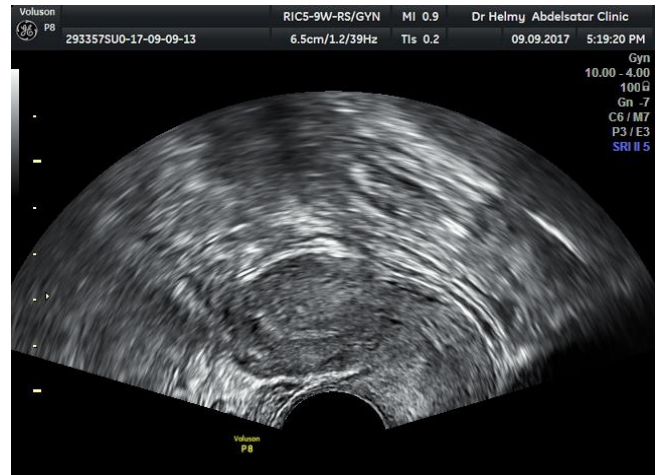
Transvaginal ultrasound shows ear sign and asymmetrically enlarged uterine walls.
